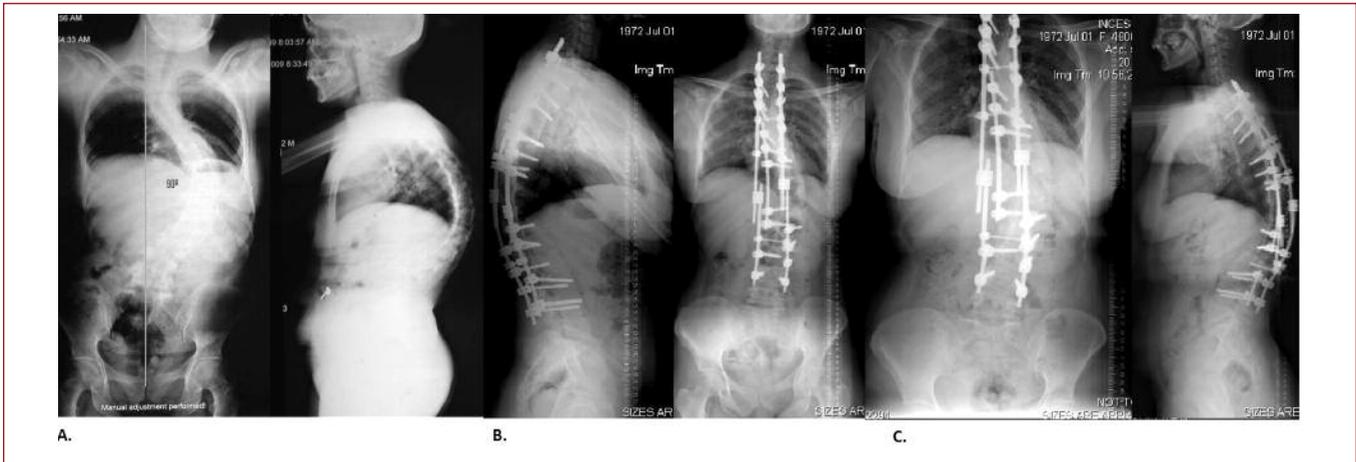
Patient 2 A. Antero-posterior and lateral X-ray before surgery B. Antero-posterior and lateral X-ray after surgery C. Antero-posterior and lateral X-ray after follow-up period.
